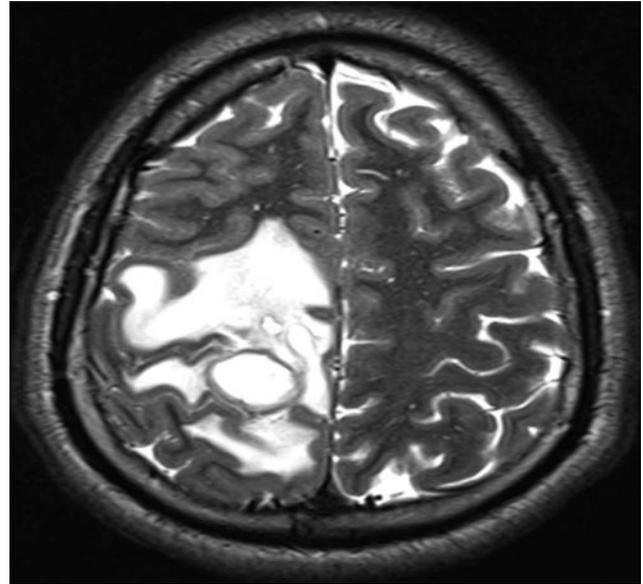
Axial T2-weighted magnetic resonance imaging sequence depicting a right parietal intraparenchymal abscess with surrounding hyperintense vasogenic edema.
